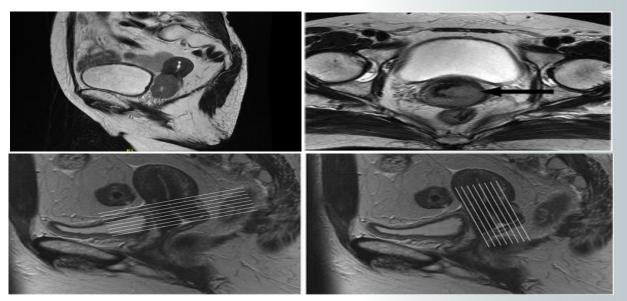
MRI sagittal (a) and axial (b) images showing high signal intensity tumor as opposed to low signal cervical stroma. MRI cuts in para-sagittal and para-axial planes (c).
